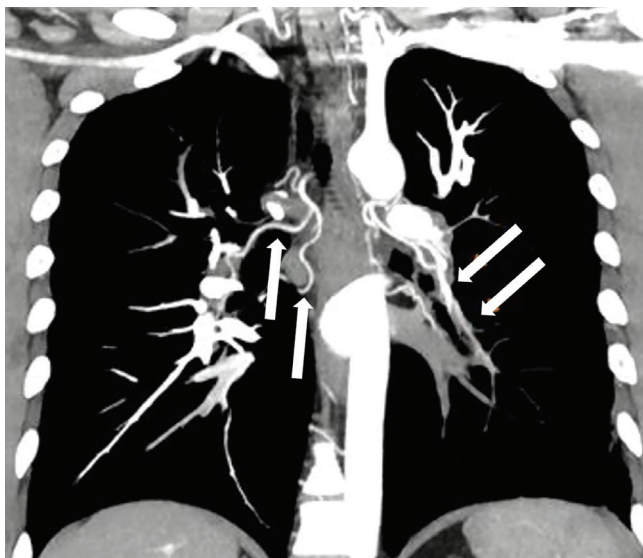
Coronal reformatted computed tomography pulmonary angiography image in chronic thromboembolic pulmonary hypertension. Segmental occlusion of the left lower lobe pulmonary artery is evident. Segmental occlusions are also present in the right lung. Marked bronchial artery hypertrophy (white arrows) is best observed on the coronal maximum intensity projection image.
